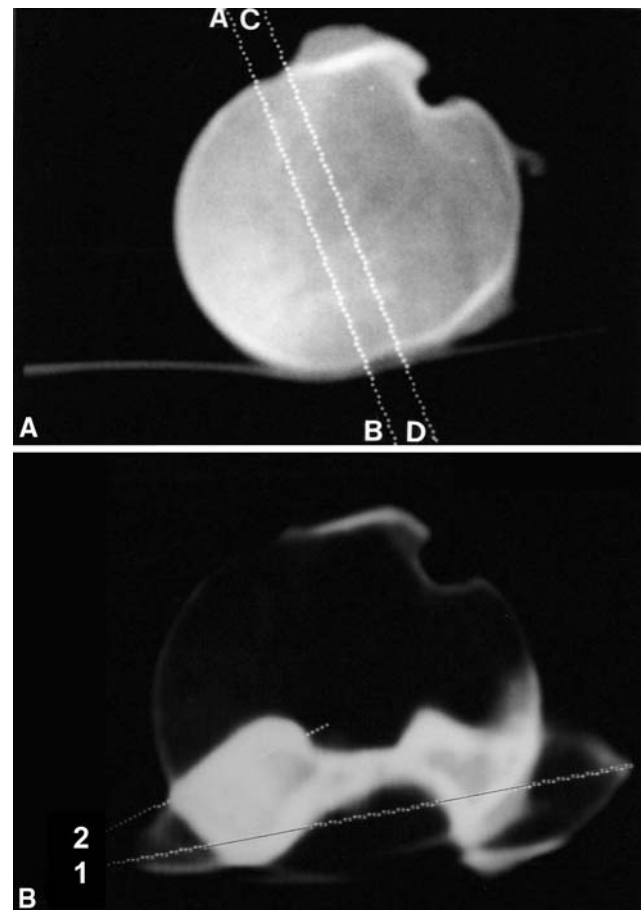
The computed tomography scan method is shown. (A) Line A-B marks the boundaries of the humeral head articular surface using the limits of the subchondral bone (Lauman and Kramps [34]), whereas line C-D marks the anterior and posterior depressions corresponding to the insertion of the articular capsule (Bernageau [2]). These two lines are approximately parallel. (B) Line 1 defines the epicondylar axis. Line 2 defines the humeral head axis.
